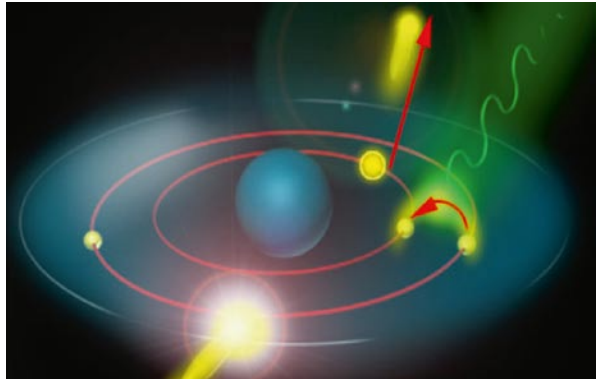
Characteristic X-ray generation
